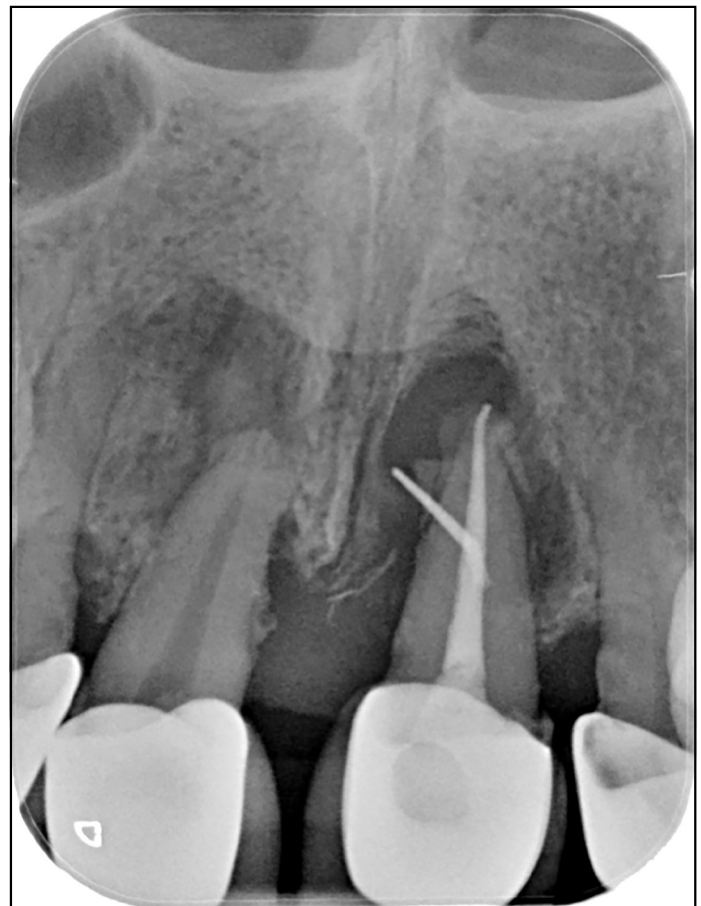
Pre-operative PA radiograph. A gutta-percha traced the buccal sinus tract to the periradicular lesion on maxillary left permanent central incisor
